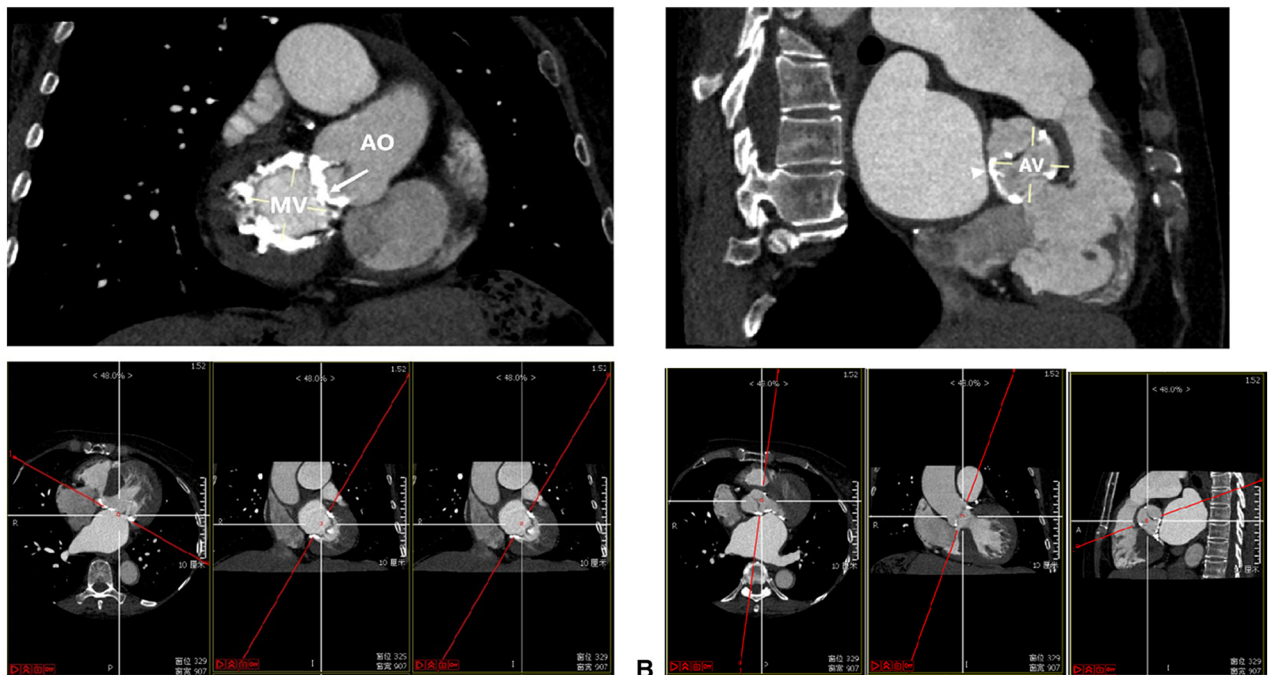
Representative patterns of severe MAC in patients with symptomatic MR. Images from gated, contrast-enhanced cardiac computed tomography are shown. A, Severe mitral annular calcification. B, Severe aortic annular calcification. Mitral annulus complete calcification often coexists with aortic annular calcification. *AO*, Aorta; *MV*, mitral valve; *AV*, aortic valve.
